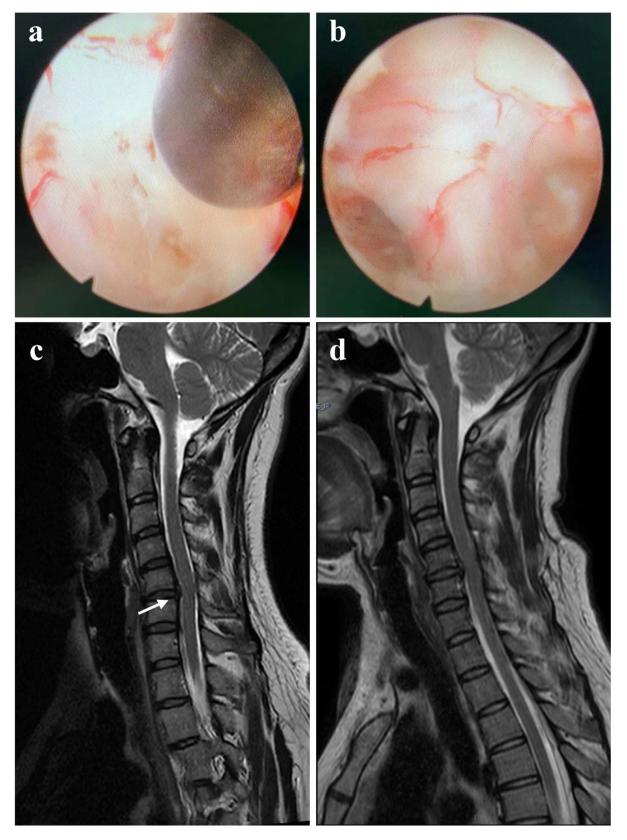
A 57-year-old female patient presented with neck and left arm pain. Endoscopic image showing a herniation (a) and decompression of the nerve root (b). Preoperative T2-weighted MRI showed a herniation (white arrow) at the C5/6 level (c), and the herniation was removed on postoperative (3 months) MRI scans (d)
